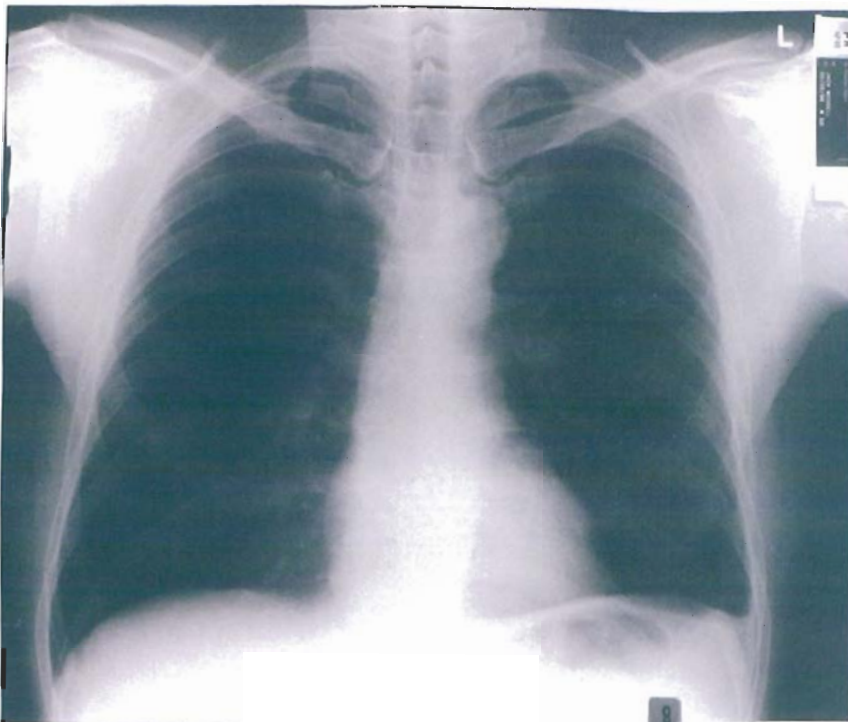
An x-ray taken on 26 March 1998 suggests a possible activity in the left costo-phrenic angle and he has just been retreated. Completely asymptomatic. 29 months survival to date with normal or near normal x-ray. Death reported from coronary disease, september 2004.
